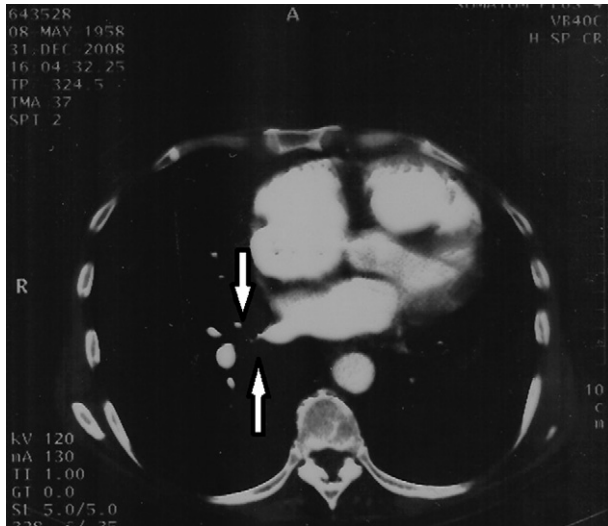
Thorax CT showing complete occlusion of the right pulmonary artery (arrows).
